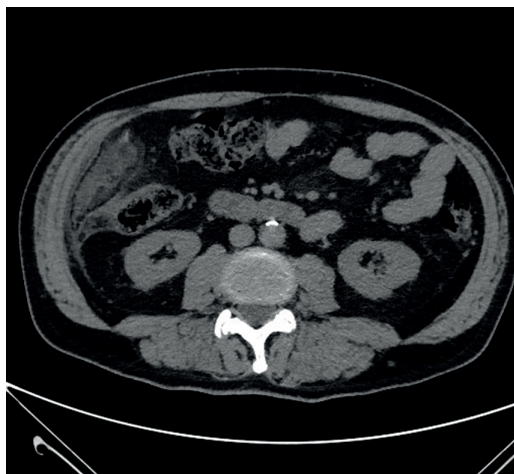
Axial image of baseline unenhanced CT shows oval thickening of fat tissue in the right lumbar region associated with surrounding omental stranding and periferic spontaneously hyperdense vascular structure (white arrow).
